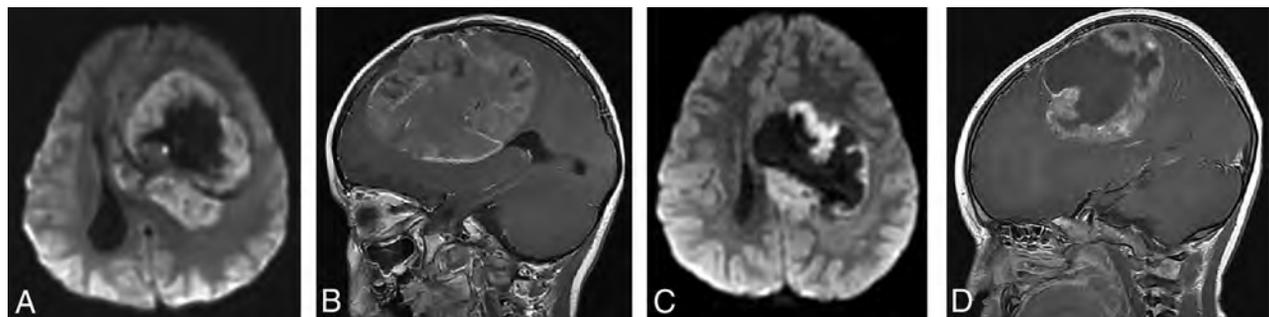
(A and B), A 4-year-old girl with a molecular diagnosis of high-grade glioma (GBM_MYCN). Axial DWI (A) and sagittal postcontrast T1-weighted (B) images demonstrate a large mass centered in the left frontal lobe with prominent necrotic/cystic areas centrally and diffusion restriction and moderate heterogeneous enhancement of the solid component. (C and D), A 4-year-old boy with a molecular diagnosis of ependymoma (EP_REL). Axial DWI (C) and sagittal postcontrast T1-weighted (D) images demonstrate a large mass centered deep in the left hemisphere with prominent necrotic/cystic areas centrally and diffusion restriction and moderate heterogeneous enhancement of the solid component. Note the similarities in age and imaging appearance between these 2 patients with different molecular diagnoses.
